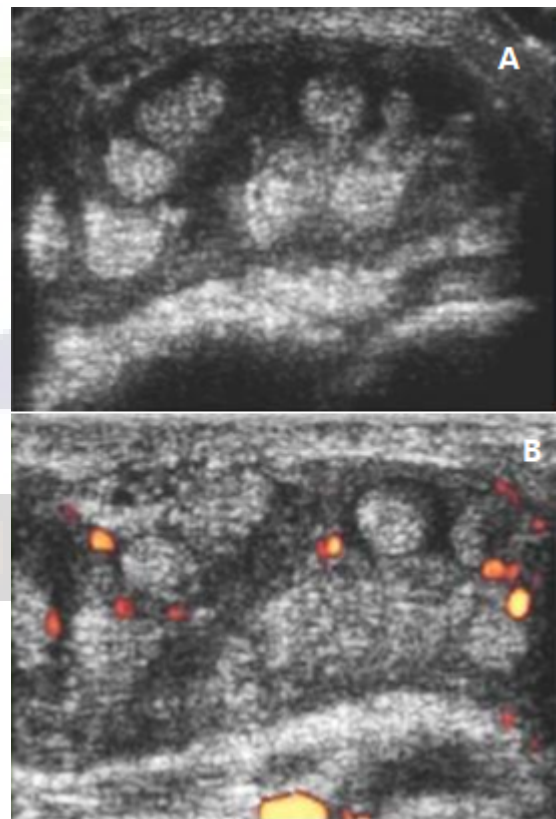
Flexor tenosynovitis a) Axial US image and b) power doppler shows thickening of tendon sheath and hypochoic collection with increased vascularity.
